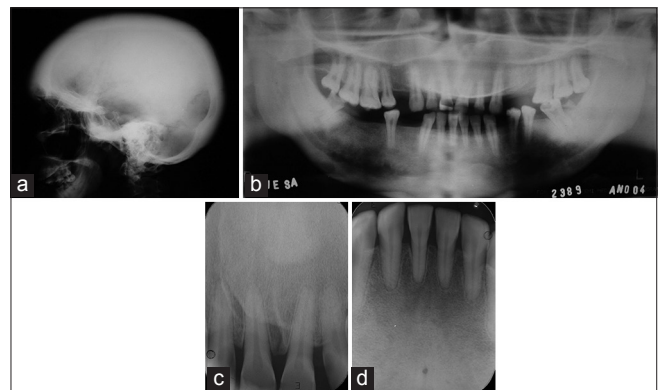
(a) Radiograph of skull showing improvement of the “ground-glass” appearance of calvarium; (b) Panoramic radiograph showing improvement of the pattern of trabecular bone; (c) Intraoral radiograph showing restoration of lamina dura of maxillary anterior teeth; (d) Intraoral radiograph showing restoration of lamina dura of mandibular anterior teeth
